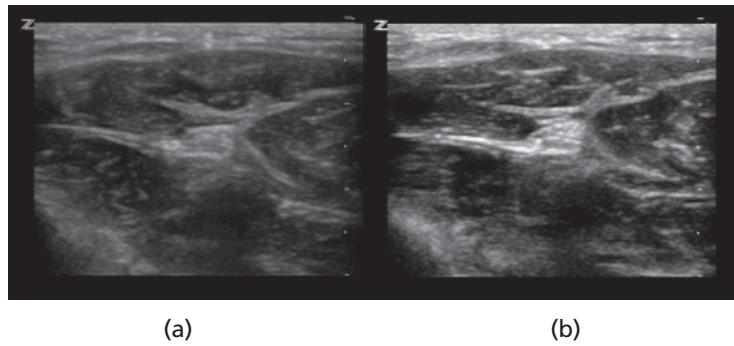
Ultrasonic images of a radial nerve: (a) Imaged at a sound speed of 1540 m/s. (b) Imaged at a sound speed of 1650 m/s. Note the differences in contrast resolution, boundary clarity, and detail resolution seen in image (b) compared with image (a). These images were obtained with a linear transducer (L10-5) operated under a frequency compounding modality at a depth of 3 cm.
